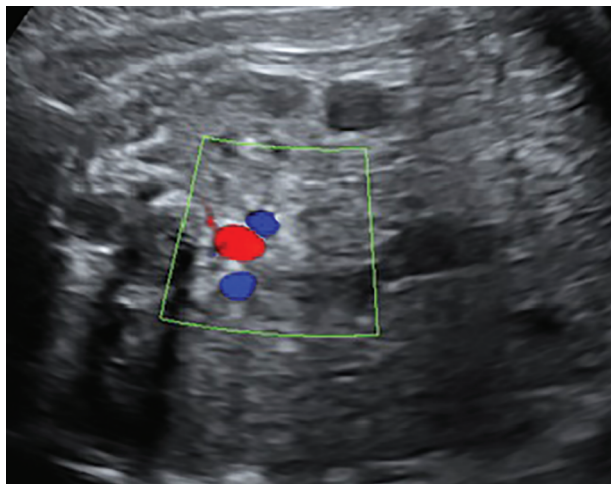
Transverse view of the fetal abdomen slightly below the renal veins. Color Doppler demonstrating the same direction of the blood flow in the both vessels, representing duplicated IVC
